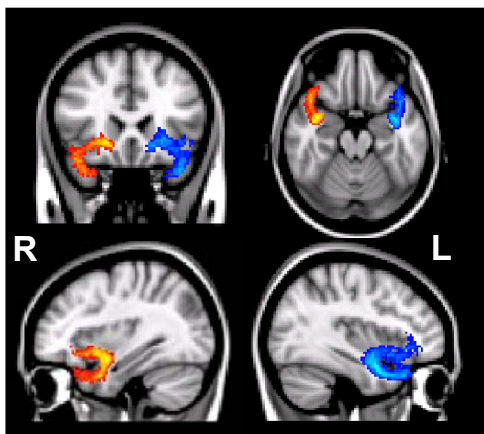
Mean left (blue) and right (red) uncinate fasciculus reconstructed in healthy controls, overlaid onto a T1-weighted template.
